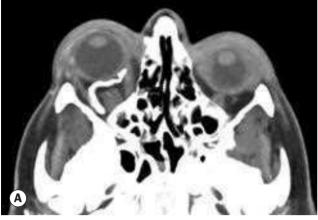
CT in direct carotid–cavernous fistula. (A) Axial CT image showing enlargement of the right superior ophthalmic vein; (B) coronal view showing enlargement of extraocular muscles on the right
